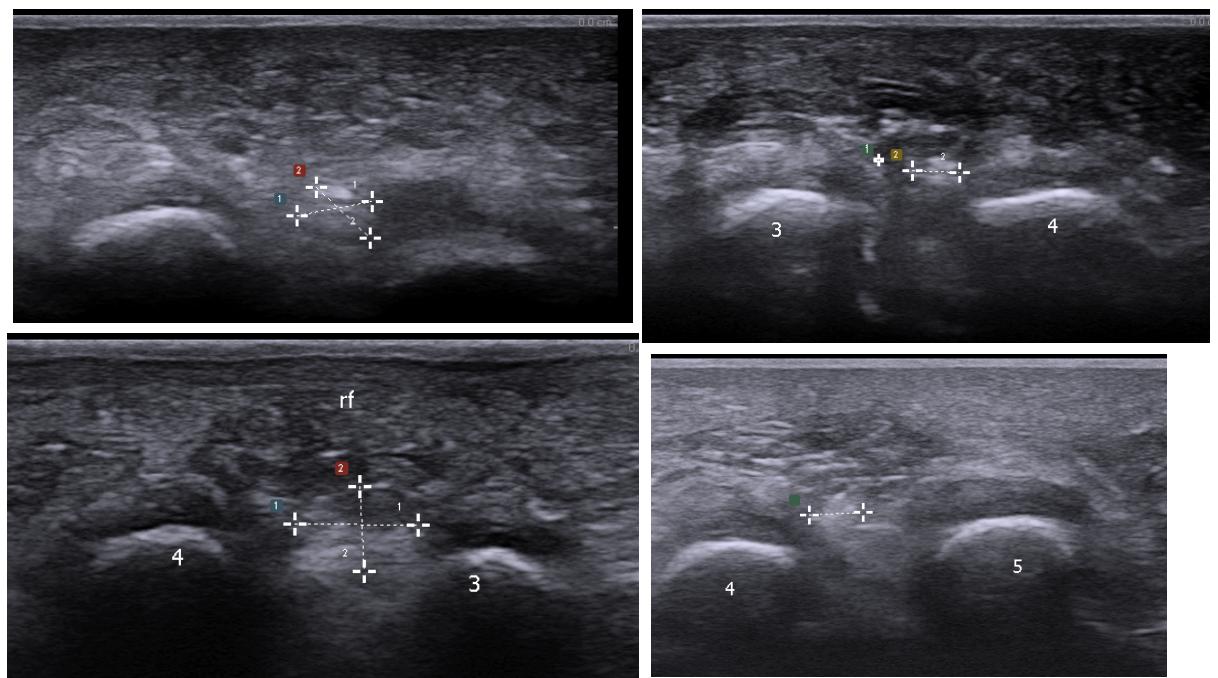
Ultrasound images of the plantar forefoot. Measurement tool indicates the size and location of FFN (authors own images, 2018)
